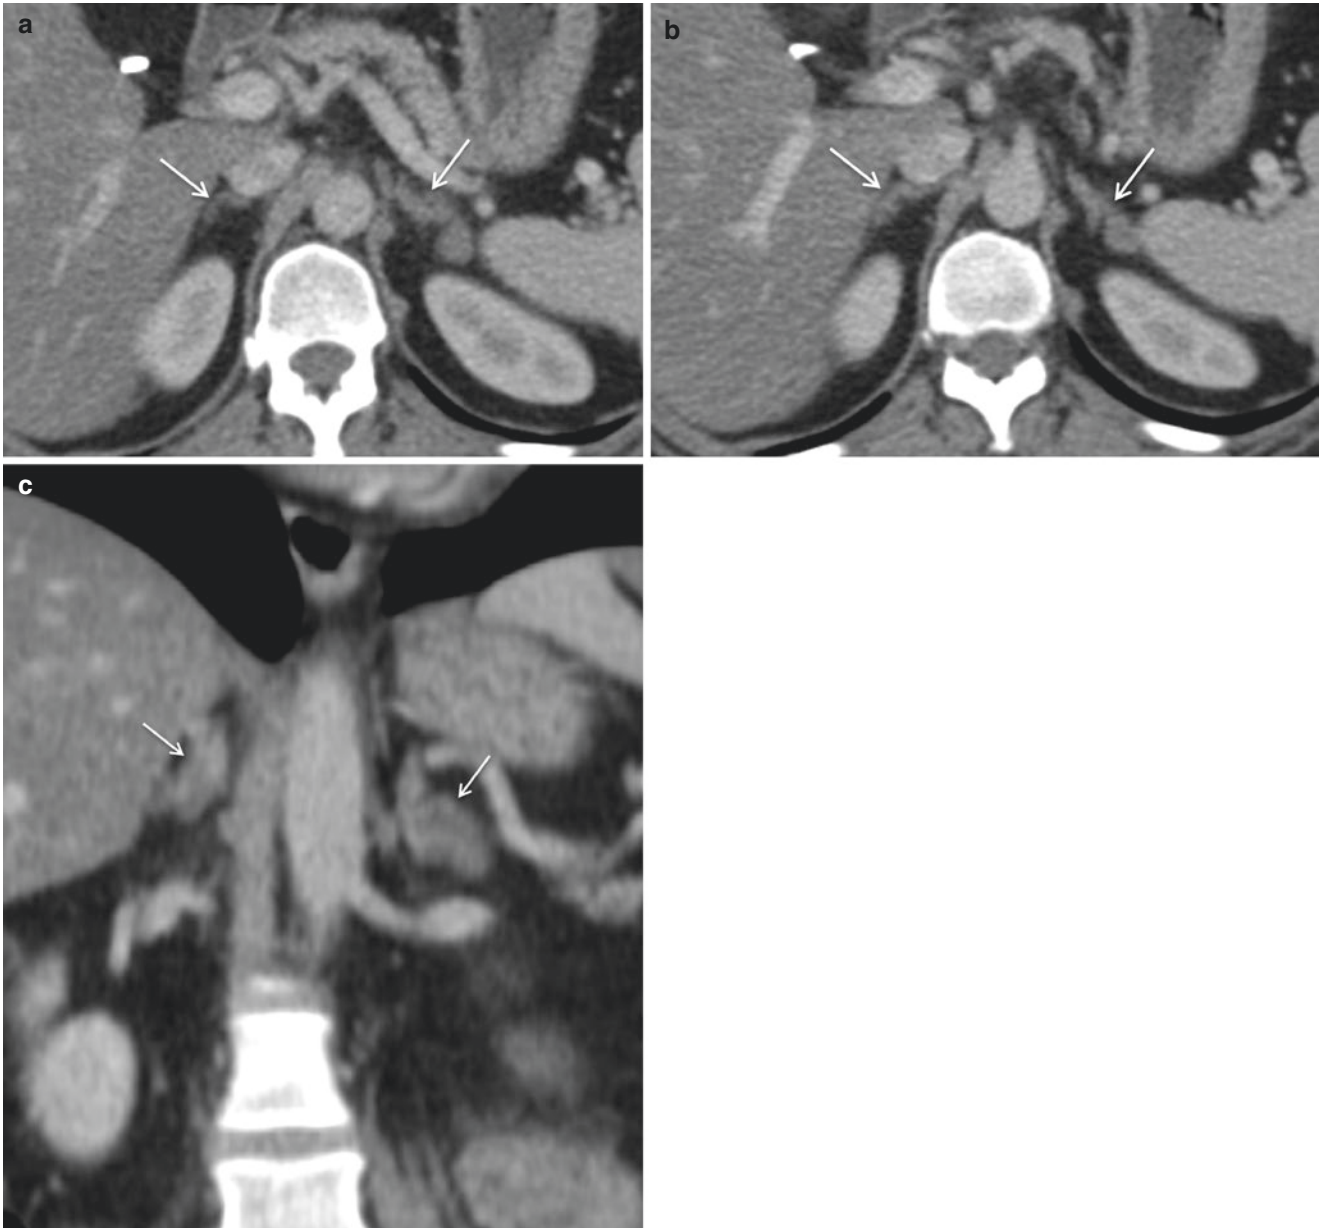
ACTH-independent macronodular adrenal hyperplasia (AIMAH). Post-contrast CT images showing multinodular enlargement of both adrenal glands (*white arrows*)
